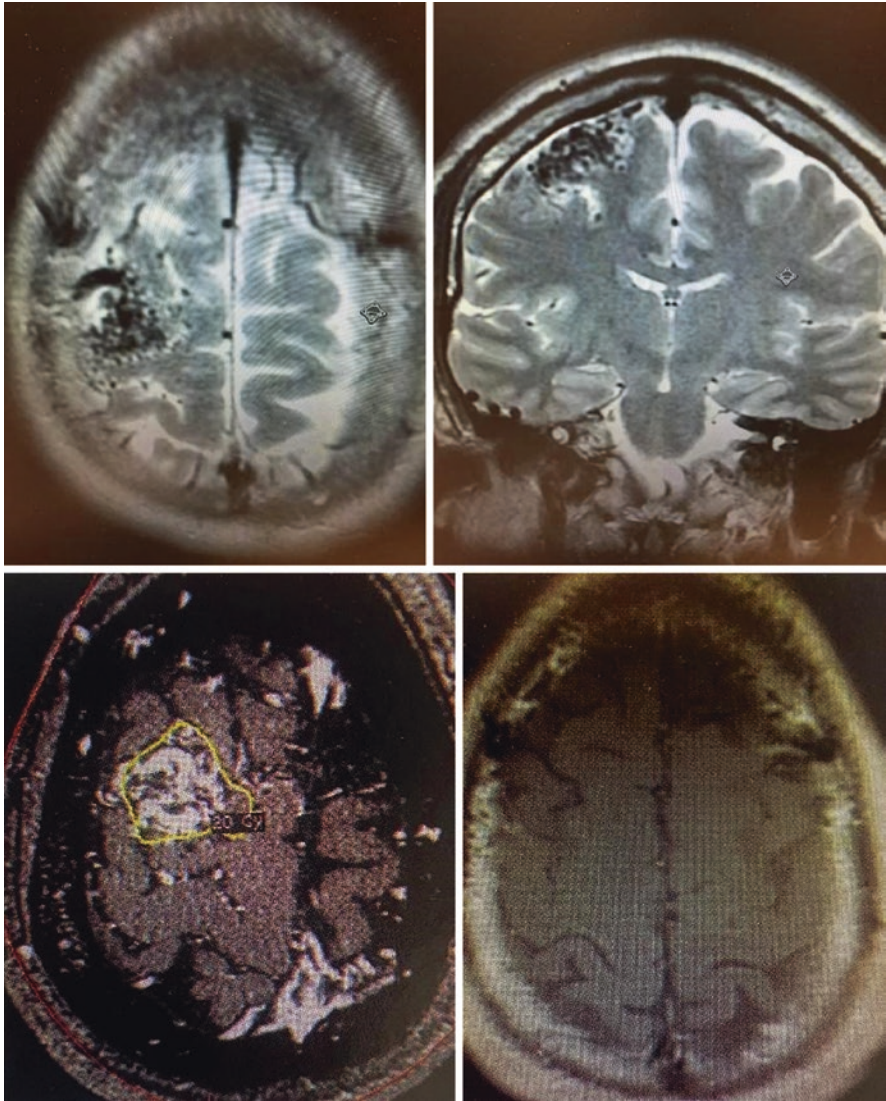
This is a 28-year-old man who presented with headaches and was found to have a 2.5 cm right frontal AVM (a: axial T2 weighted MRI; b: coronal T2 weighted MRI). Gamma Knife was performed (c: day of Gamma Knife treatment, postcontrast T1 axial image). Three years later the AVM is gone (d) and he has no symptoms
